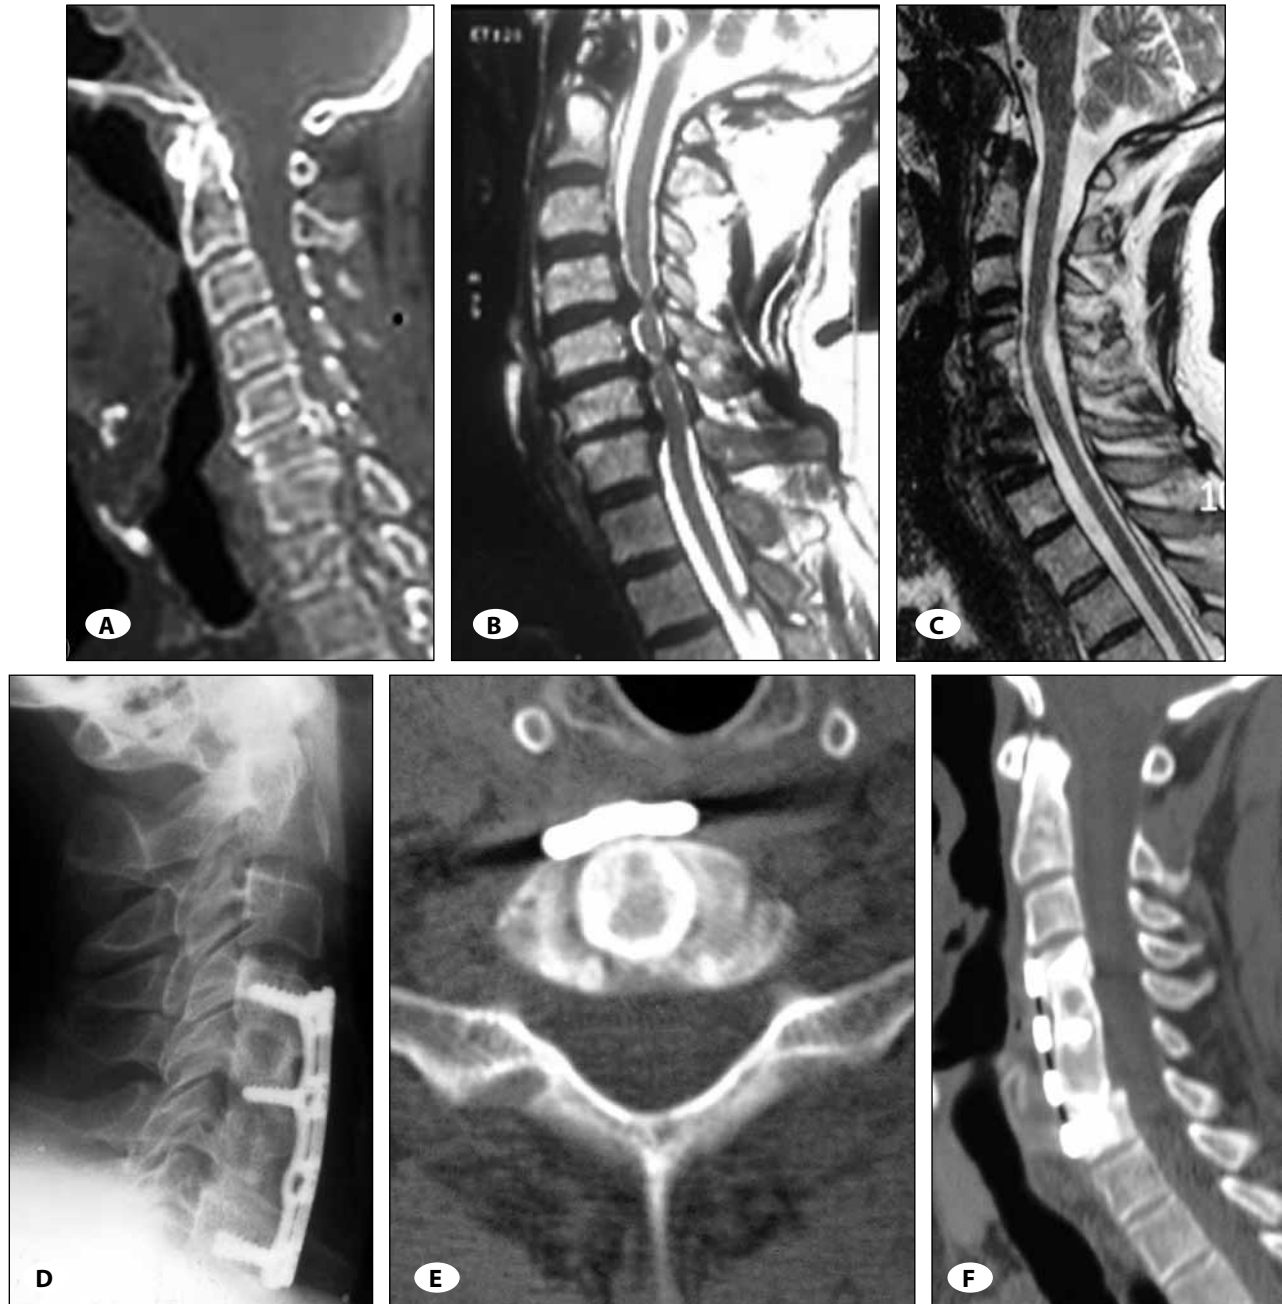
A) CT scan of the cervical spine (lateral view) showing cervical spondylosis and spondylotic ossification. B) T2W MRI (sagittal section) showing cervical spondylotic myelopathy pre-operative. C) T2W MRI (sagittal section) showing post-operative period (2.3 years). D) Post operative X-ray cervical spine showing C5-C6 corpectomy, anterior iliac crest fusion and anterior cervical plate (2.3.years after the operation). E-F) Postoperative CT is showed to fusion and decompressed spinal canal.
